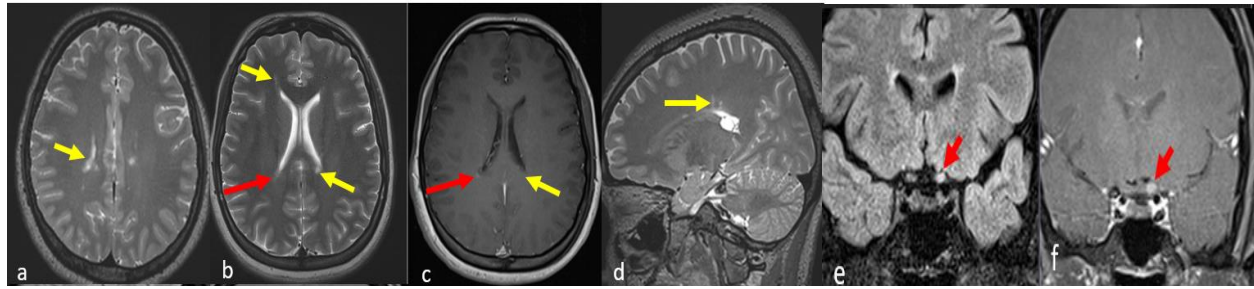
MRI of the brain and orbit in axial T2W (a&b) T1W post-contrast; (c) sagittal T2W; (d) and coronal flair; (e) and T1 fat sat post-contrast; (f) multifocal hyperintense periventricular lesions, the majority ovoid in shape (yellow arrows), were seen. Some lesions were perpendicular to the lateral ventricle, giving rise to Dawson's fingers (yellow pointer in d). Enhancement of the lesion can be appreciated (red arrow in c). The left optic nerve was hyperintense and swollen, demonstrating some enhancement post-contrast (red contrast (red arrow in e and f))
